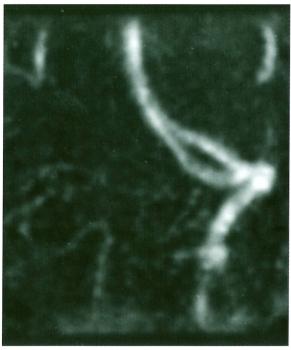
Case 24 A) Computed tomography showing a subarachnoid hemorrhage, located primarily in the pre-pontine cistern. B) Right vertebral angiogram on day 2, anteroposterior view, showing a dissecting aneurysm just distal to origin of the posterior inferior cerebellar artery. C) Right vertebral artery angiogram after coil embolization of the dissection site. D) Left vertebral artery angiogram after coil embolization of the dissection site. E) Follow-up magnetic resonance angiogram 6 months after the embolization showing complete occlusion of the affected site and preservation of the PICA.
